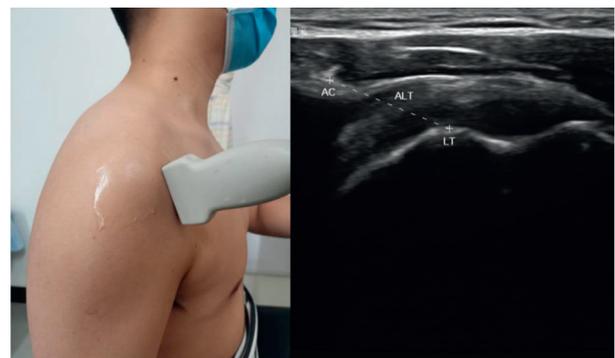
Measurement of acromion-lesser tuberosity (ALT) for shoulder subluxation by using musculoskeletal ultrasound imaging technique. AC indicates acromion; LT indicates lesser tuberosity.
